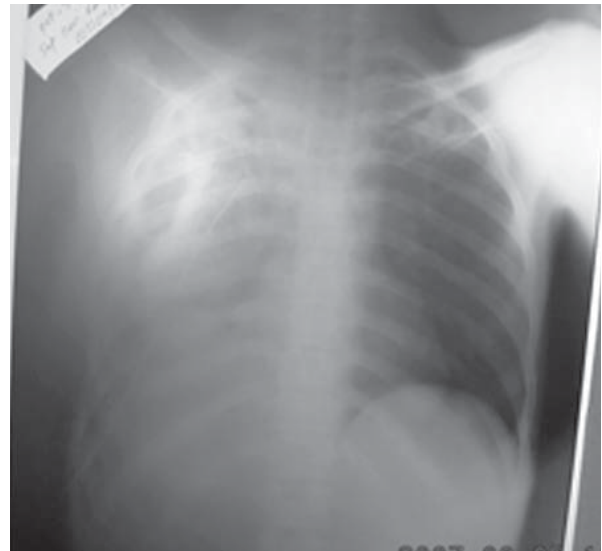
Post operative X-ray, Chest:
